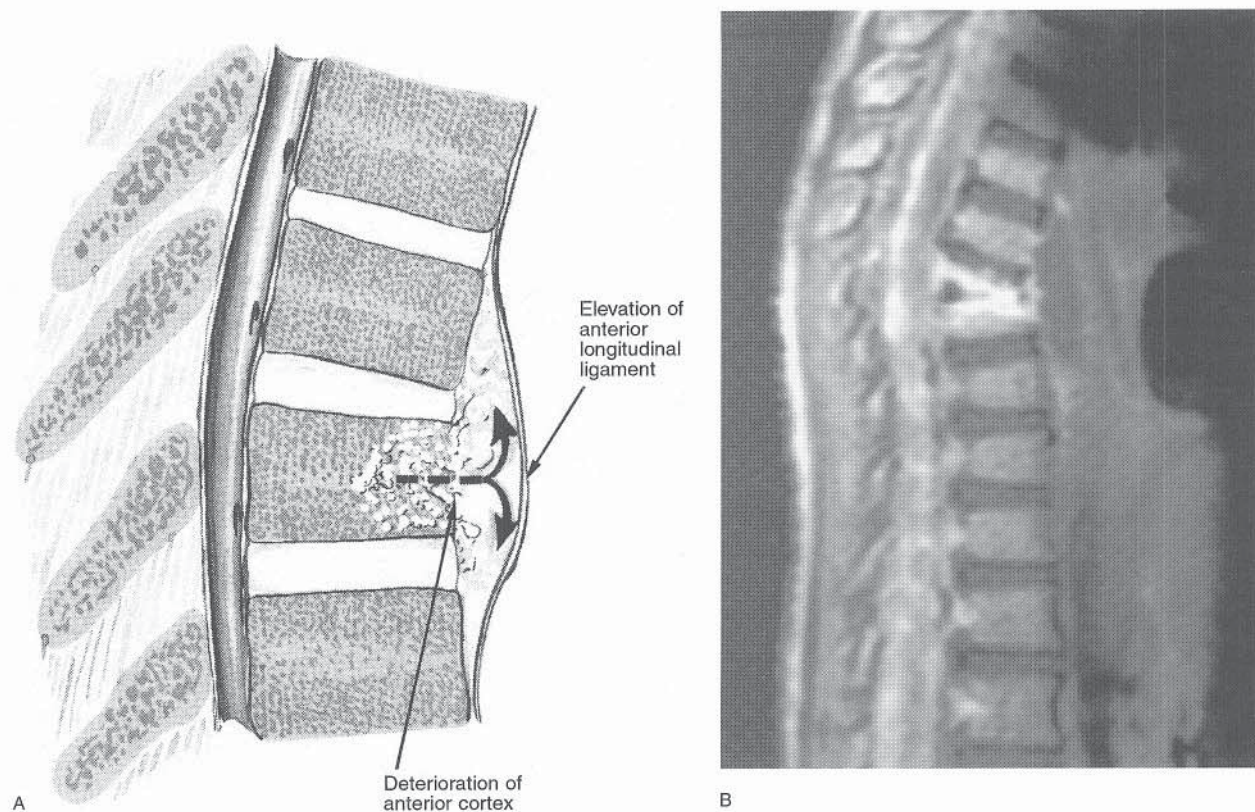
Pathogenesis of Pott's disease (tuberculosis of the spine). A, Infection egressing from bone elevates the anterior longitudinal ligament. B, MRI shows collapse of the anterior vertebral bodies and the intervening disk space as well as abscess formation anteriorly.
